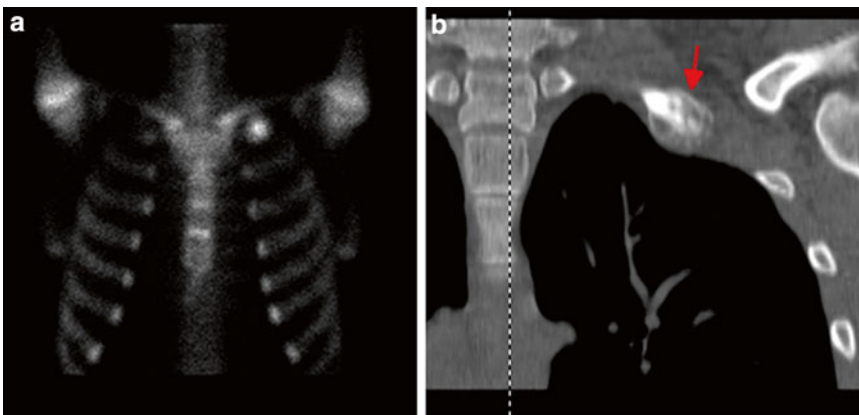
Bone scan (a) and coronal CT scan (b) images demonstrating left first rib stress fracture in a male collegiate gymnast. CT scan demonstrates healing with abundant callus formation
